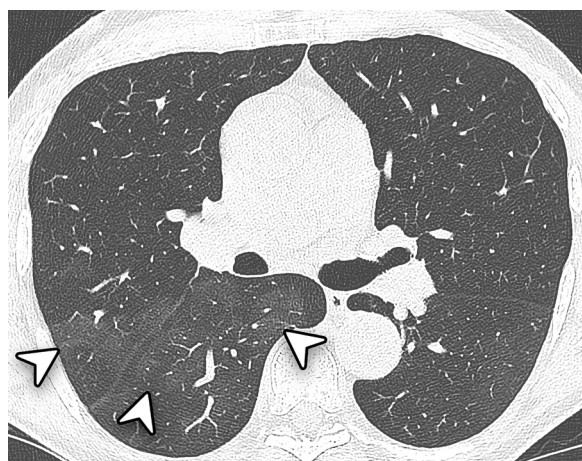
Unenhanced chest CT scan of a 58-year-old man who suffered severe COVID-19. The examination was performed 88 days after the disease onset. Axial image shows pure faint ground-glass opacity in the right upper and lower lobes (white arrowheads).
